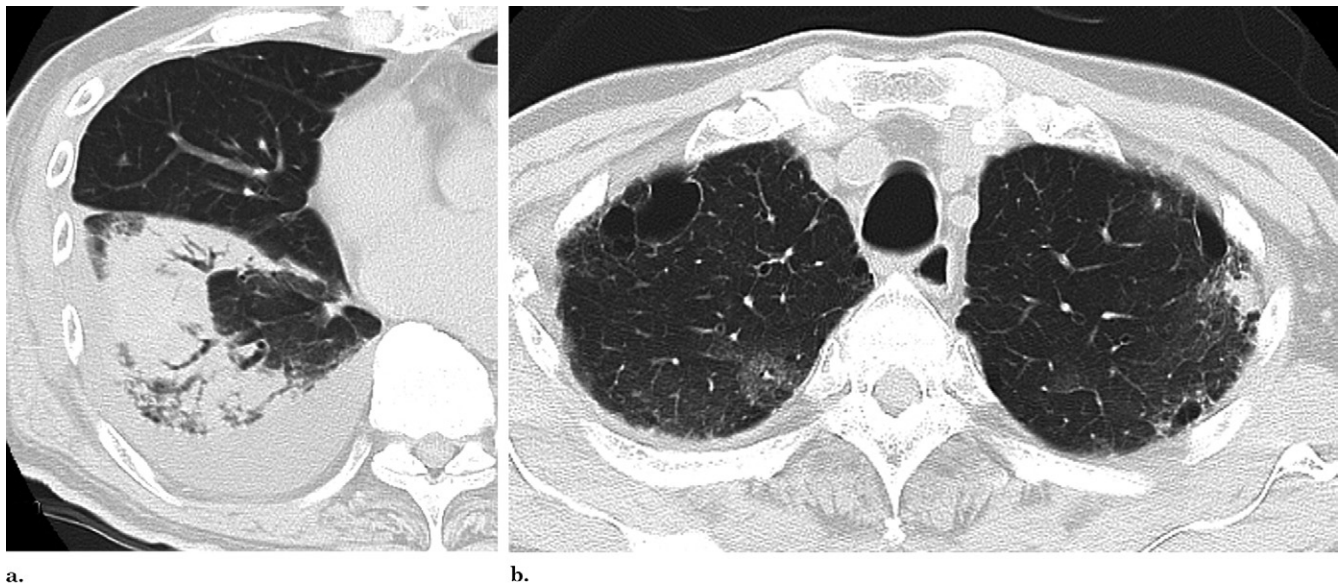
Local recurrence after stereotactic radiation for primary lung cancer in an 88-year-old man. (a) CT image 1 month after RF ablation shows peripheral-dominant consolidation in the right lower lobe. Pleural effusion is also demonstrated. (b) CT image 1 month after RF ablation shows patchy consolidations or ground-glass opacities in the subpleural area of the bilateral upper lobes.
